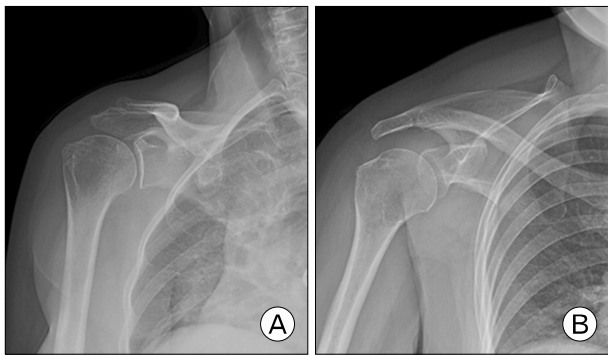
Plain radiographs of the right shoulder 1 year after surgery. (A) Anteroposterior and (B) 20° caudal tilting view.
